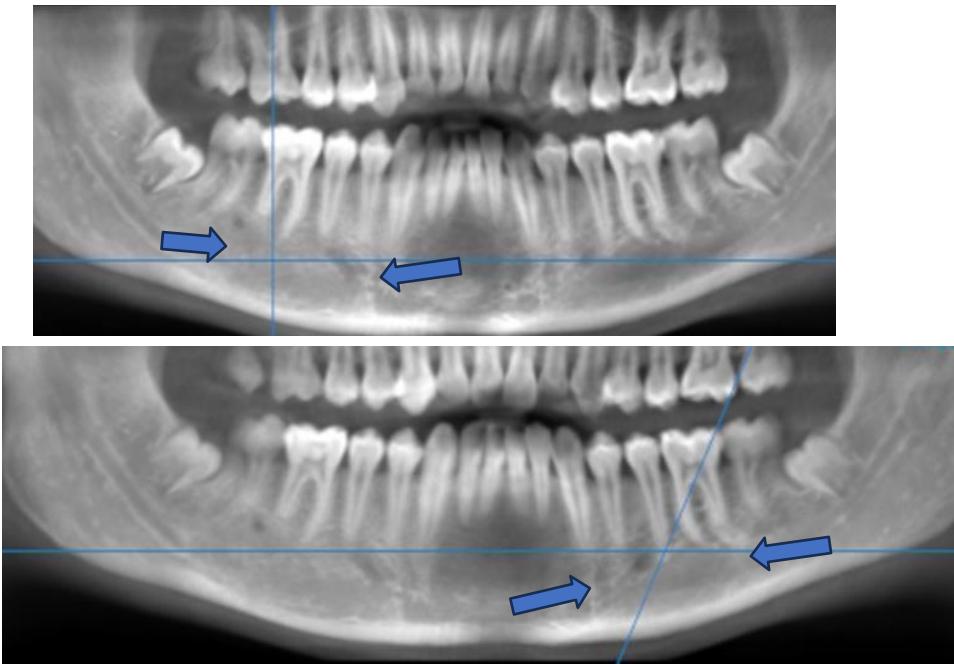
8 months post op CBCT
